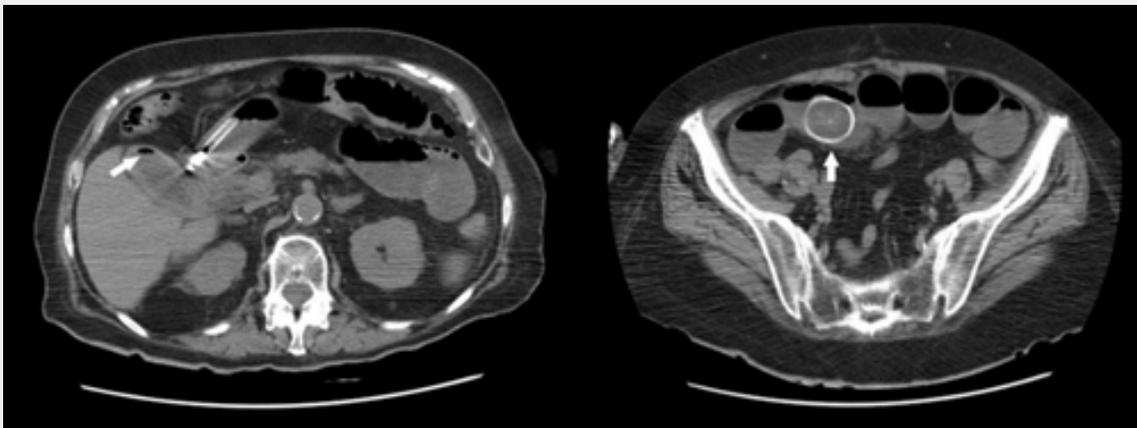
CT of the abdomen: stones in the terminal ileum, evidence of small bowel obstruction, and air in the gallbladder.
